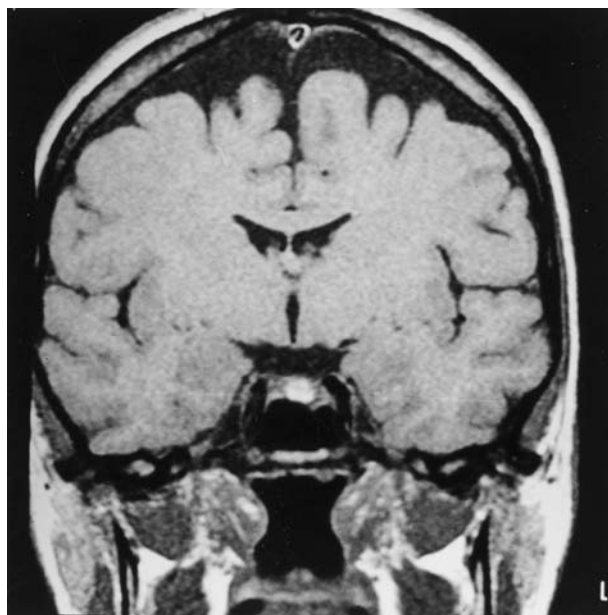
Case I: Coronal section of a T1-weighted magnetic resonance image.
